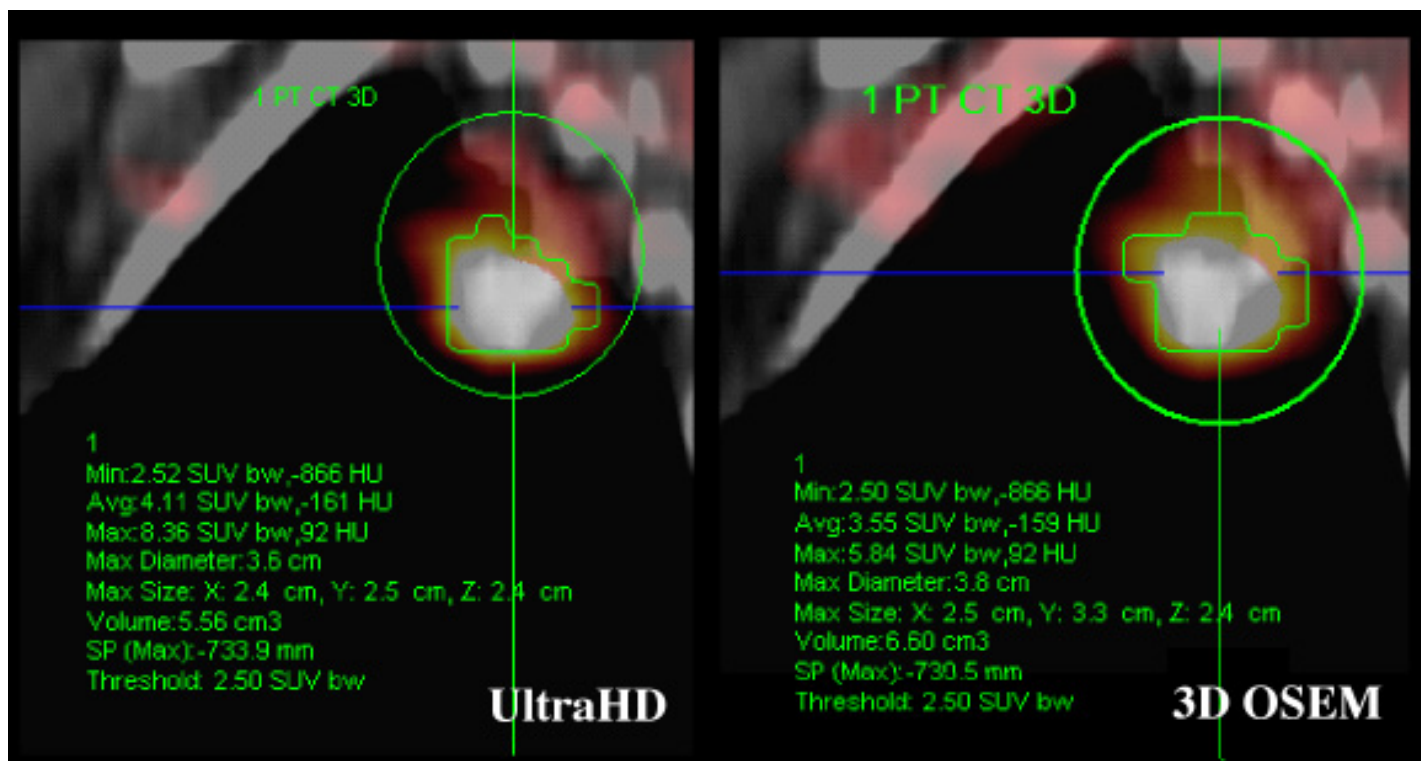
Comparison of SUVs measured for the same lesion when reconstructed with ultraHD•PET (3it12s 0mm filter; on the left) or 3D OSEM (2it24s 5mm filter; on the right). Both VOIs were generated using the 3D ellipsoid isocontour tool with an absolute threshold of 2.50 SUV_{BW}. The maximum and average SUVs are higher for the ultraHD•PET reconstruction and volume of the VOI is smaller. This is due to the reduced partial volume error associated with ultraHD•PET reconstruction. Data courtesy of University of Tennessee Medical Center, Knoxville, TN.
